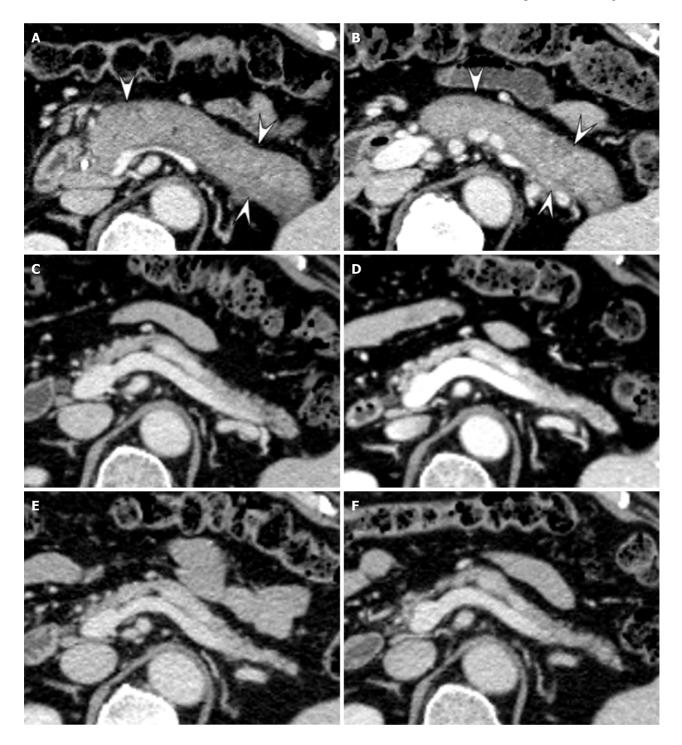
Portal venous contrast-enhanced computed tomography images of 59-year-old man with diffuse-type autoimmune pancreatitis. A: Initial computed tomography showing diffuse enlargement of the pancreas with capsule-like rim (arrowheads); B: One month later, pancreatic volume had decreased (relative volume change 683%) and capsule-like rim was observed; C: Six months later, pancreatic volume had decreased further (relative volume change 207%) and no capsule-like rim was observed; D-F: Relative volume changes after 12, 54 and 86 months were 224%, 21.5% and 20.6%, respectively.
